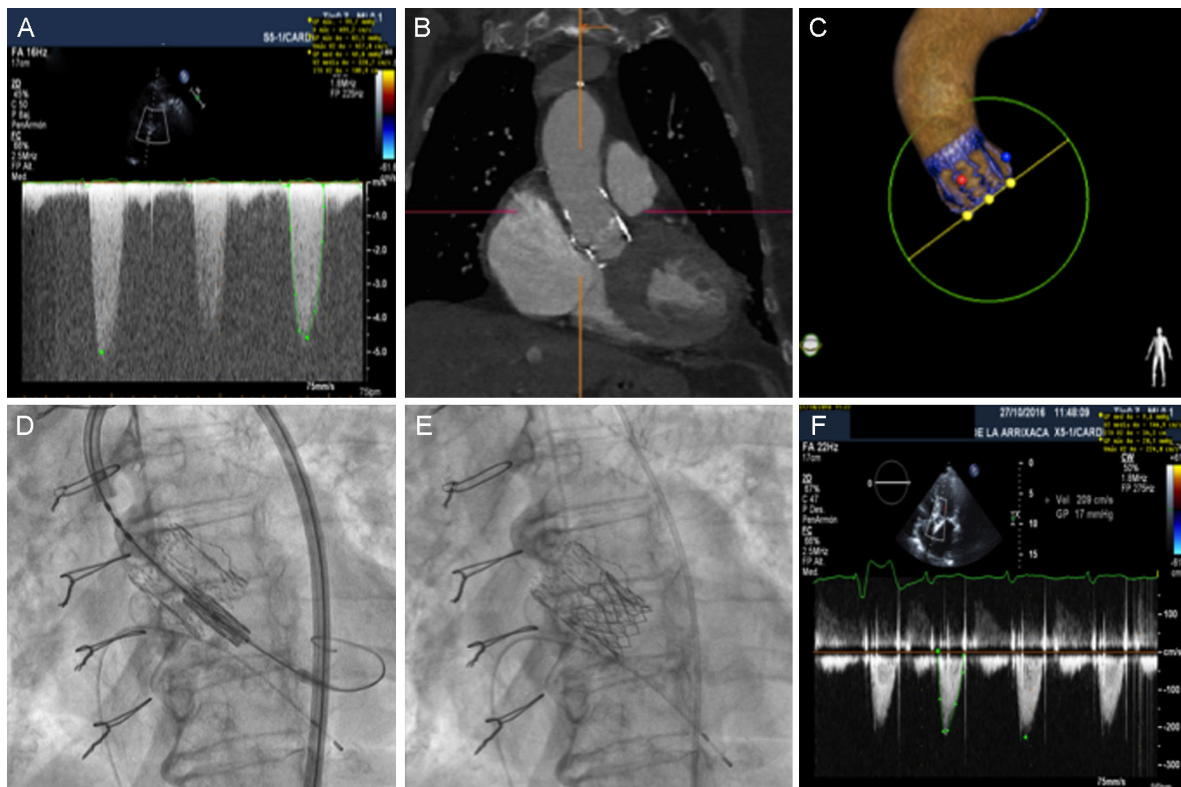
transvalvular gradient of the degenerated prosthesis. B: computed tomography image of the Perceval prosthesis. C: Heart Navigator image for planning the procedure. D: alignment of the SAPIEN 3 prosthesis during the valve-in-valve procedure. E: angiographic result, which revealed a position slightly below the edge of the Perceval prosthesis. F: optimal transvalvular gradient at discharge, after implantation.
